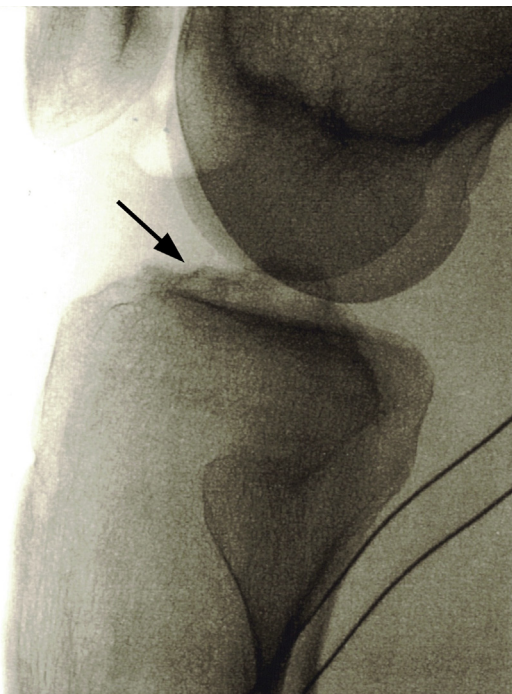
Final intraoperative lateral radiograph of the right knee confirming a successful reduction of the anterior cruciate ligament tibial spine avulsion (arrow).
